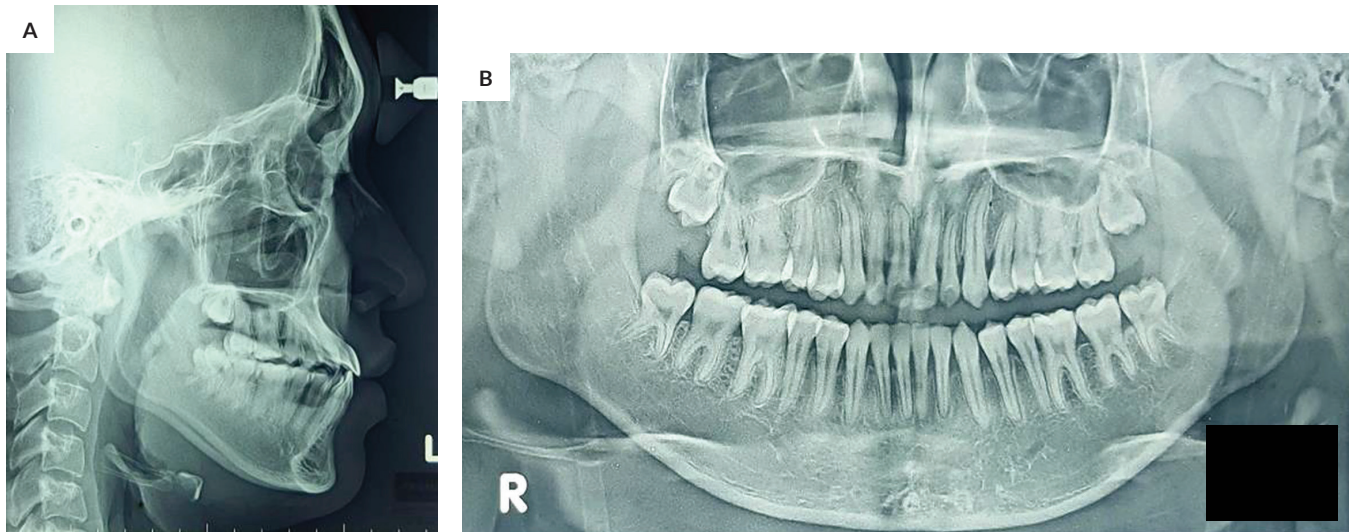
Post-treatment cephalogram (A) and orthopantomogram (B).
